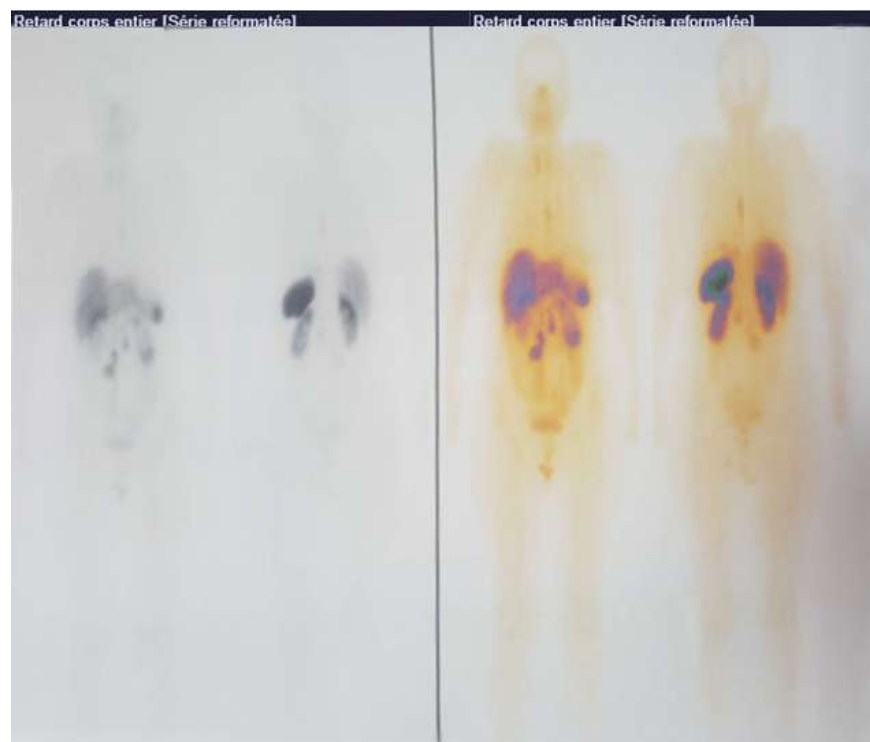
Planar image of a 99mTc-Tektrotyd® scintigraphy showing multiple foci of hyperuptake localized in the umbilical region of the abdomen (representative case).
